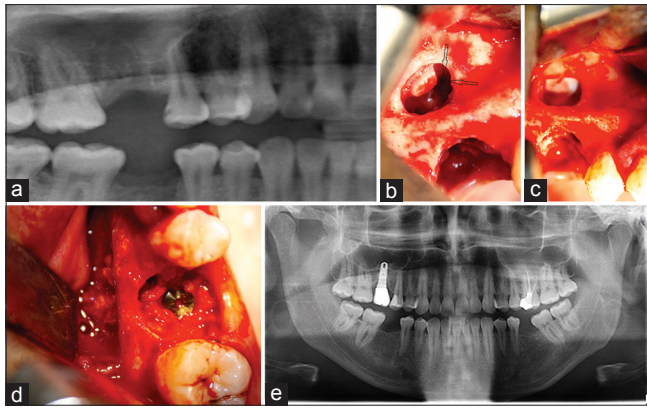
(a) Panoramic radiographic appearance of extraction tooth socket of Case 1, (b) Sinus mucosa was gently reflected without increasing membrane perforation (arrow), (c) Resorbable collagen membrane was placed on the perforation site, (d) The floor of the sinus was grafted with a particulate xenograft and an implant was placed, (e) Panoramic radiographic view, 47 months after surgery
